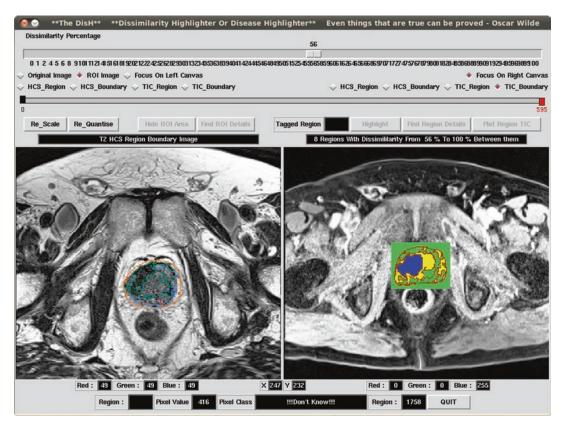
Graphical User Interface (GUI) implemented as part of the study to view T2-weighted along with the DCE-MRI image slices to correlate the different regions identified by the HCS process
